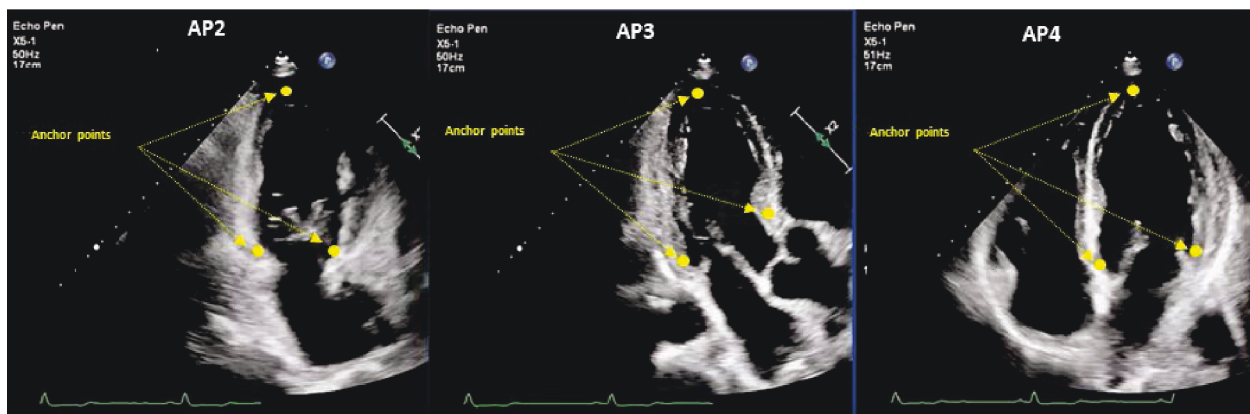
Three-point method for defining start and end points for ROI. For the apical 2-chamber view, the first point is on the basal posterior wall at the mitral annulus, the second point is at the basal anterior wall at the mitral annulus, and the third point is at the apex. For the apical 3-chamber view, one point is placed at the basal posterior wall at the mitral annulus (ventricular side), one point is placed at the apex, and one point is placed at the base of the anterior septum just proximal to the LVOT. For the apical 4-chamber view, the first point is placed on the basal inferoseptum at the mitral annulus (ventricular side), the second point is placed at the basal anterolateral wall at the mitral annulus (ventricular side), and the third point is at the apex.
